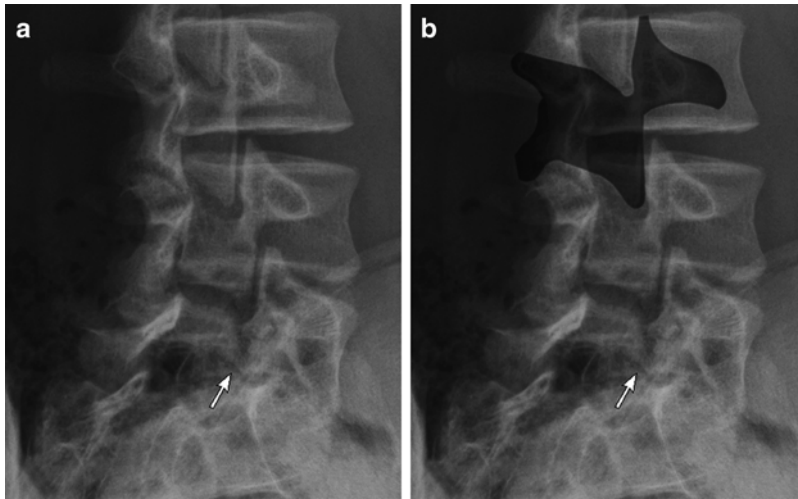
Oblique lumbar radiographs demonstrating spondylolysis (*arrows*). (a) The pars interarticularis is the “isthmus” located between the superior and inferior
